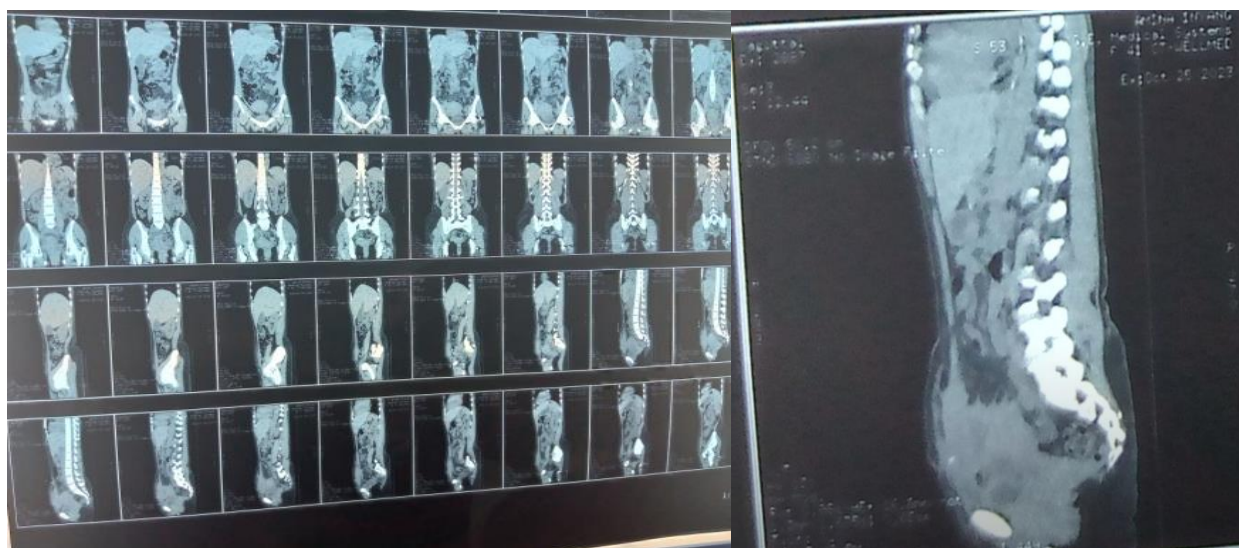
CT scan images of post myomectomy Uterocutaneous fistula
